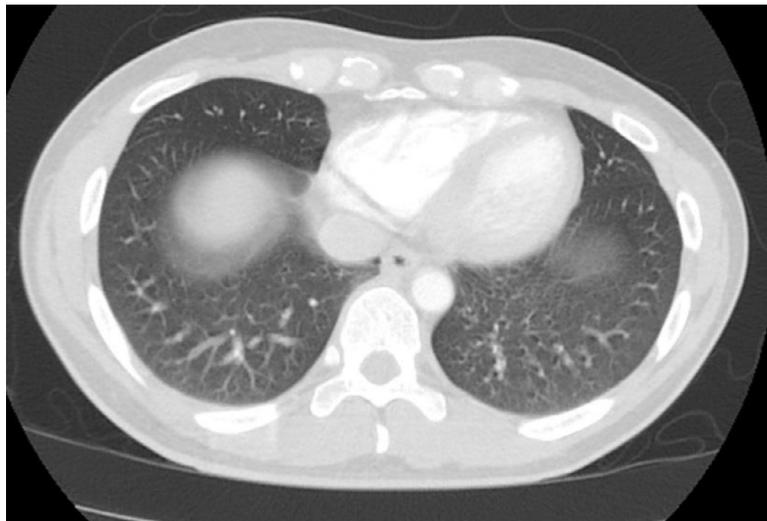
Axial computed tomography image of the chest showing emphysematous changes at the lung bases bilaterally.
